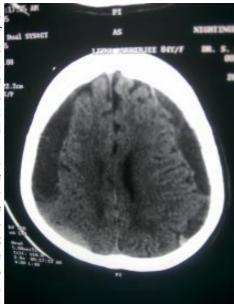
Showing CT scan of bilateral chronic subdural haematoma
